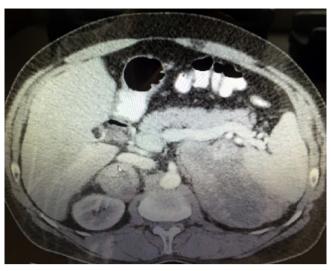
Huge metastatic adrenal mass in left side and contralateral right adrenal mass in CT
